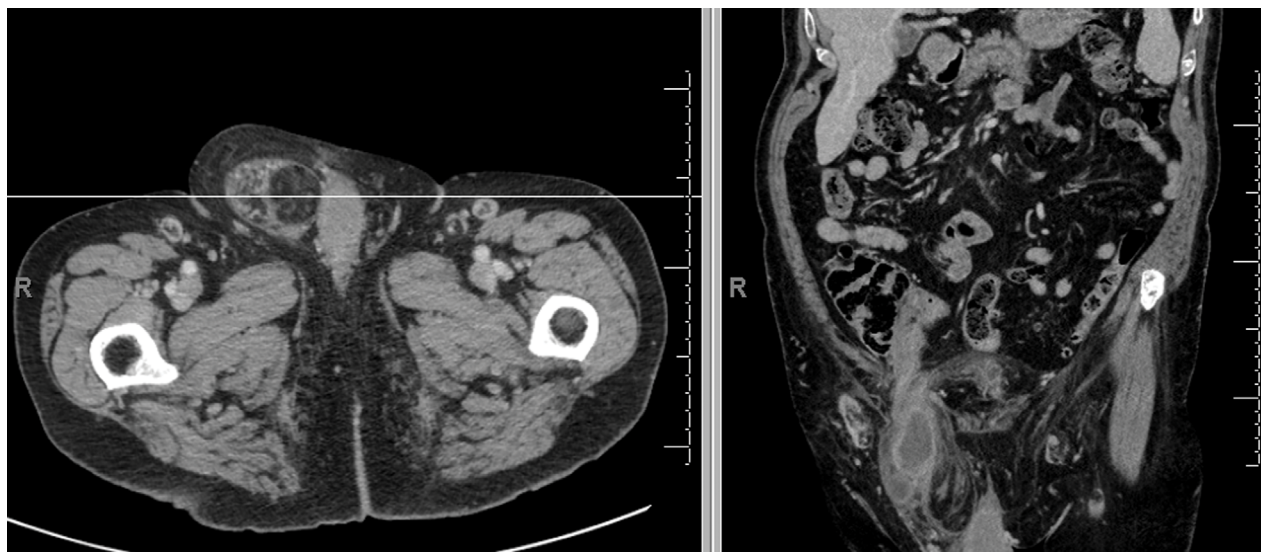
Contrast-enhanced CT scan of the abdomen showed showing a right inguinoscrotal hernia of about 67x55x165 mm with a breach of about 30 mm containing adipose tissue as well as the last ileal tract: both of these anatomic structures showed radiologic signs of acute inflammation (left: xial view; right: sagittal view).
